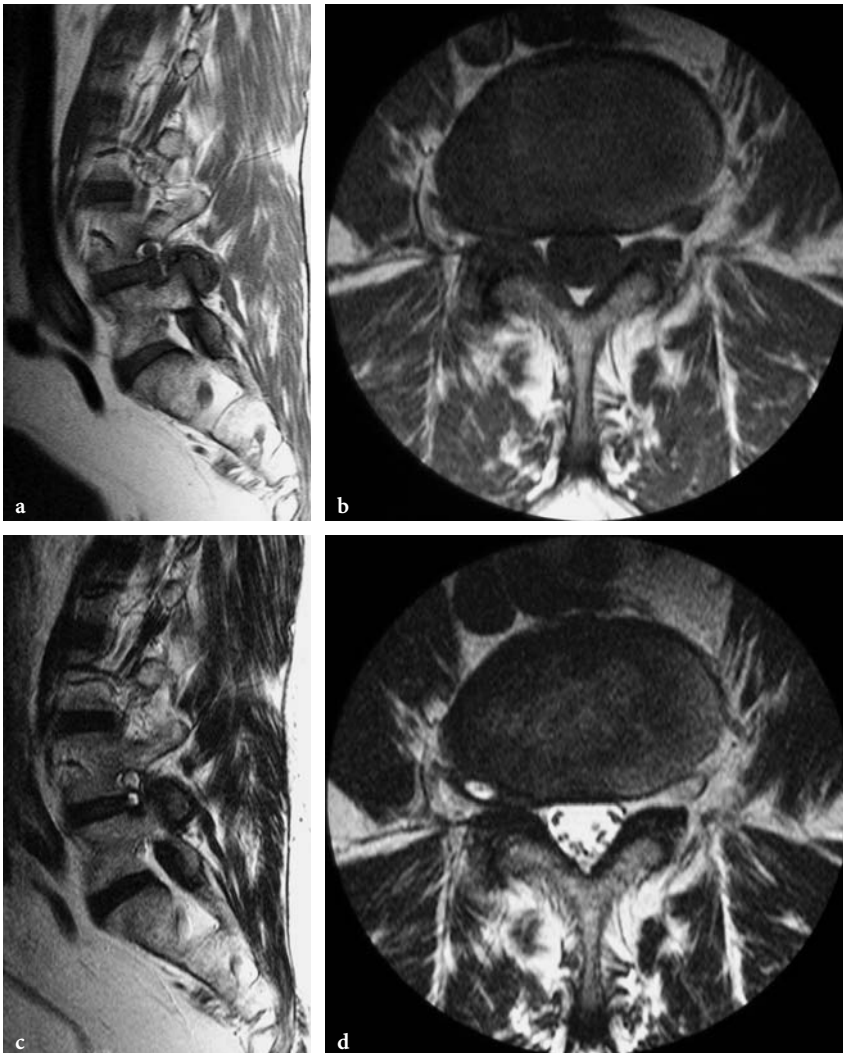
Right foraminal disc extrusion at L4–L5 in a 51-year-old man. Sagittal (a) and axial (b) T1-weighted images; sagittal (c) and axial (d) T2-weighted images. A broad-based disc extrusion extends into and beyond the right neural foramen. The herniated disc material contains a focal T2-hyperintense component, likely representing a fluid-filled disc cyst
